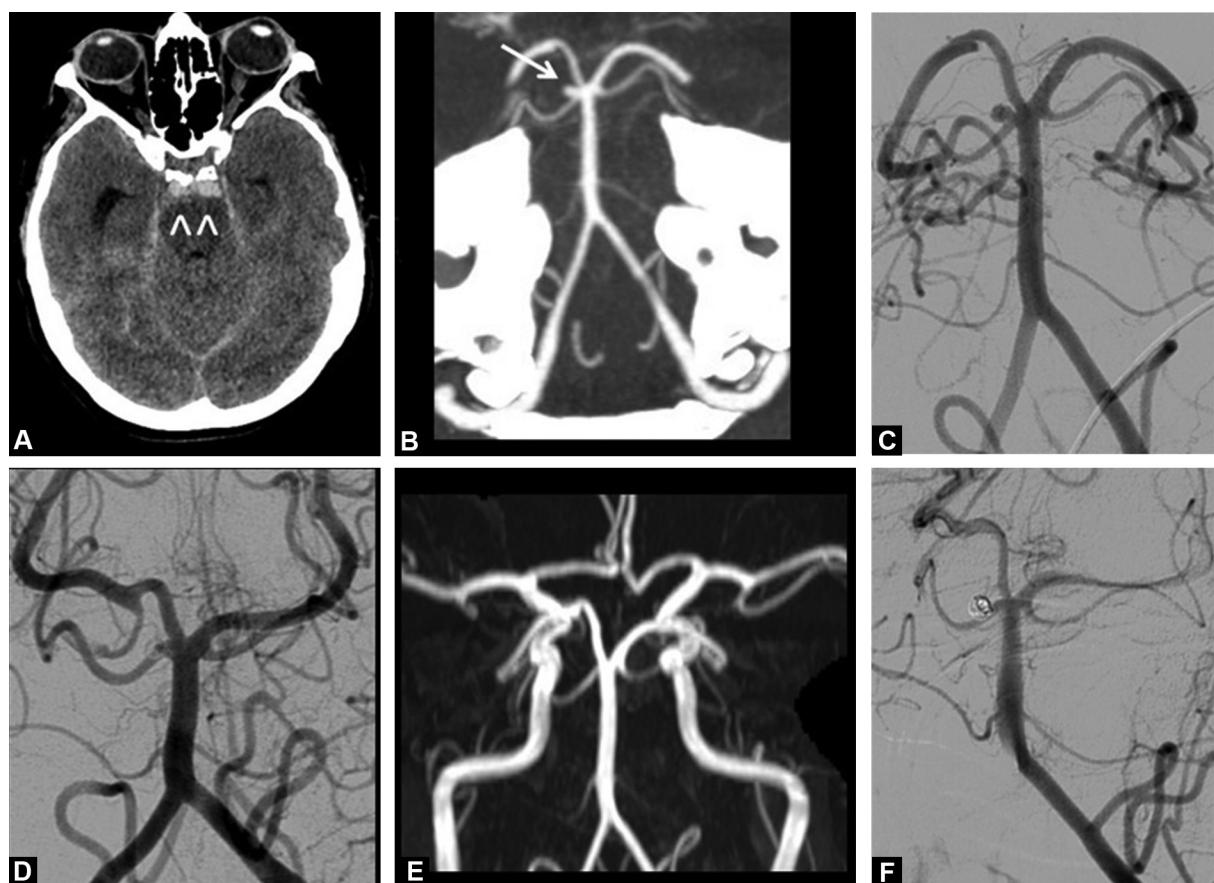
Sixty-one year old woman. Hyperdensity in the preopticine cistern on the unenhanced CT (A, arrowheads) suggestive of a subarachnoid hemorrhage due to rupture of an aneurysm located at the origin of the right superior cerebellar artery (B, coronal MIP reconstruction after enhancement, arrow). Complete exclusion of the aneurysm after endovascular coiling (cerebral arteriography C, D). No recurrence of the aneurysm on time of flight imaging performed at 6 months (E) or on the routine cerebral angiogram at one year (F).
